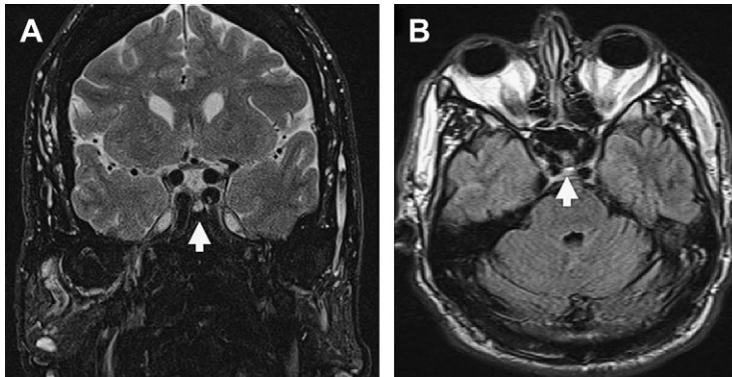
Atypical anatomy of cavernous segment of carotid artery. As indicated by the arrows on the coronal T2-weighted magnetic resonance (A) and axial fluid-attenuated inversion recovery (B) images, this patient has unusually close cavernous carotid arteries. This variant must be recognized and considered when planning a trans-sphenoidal approach.
